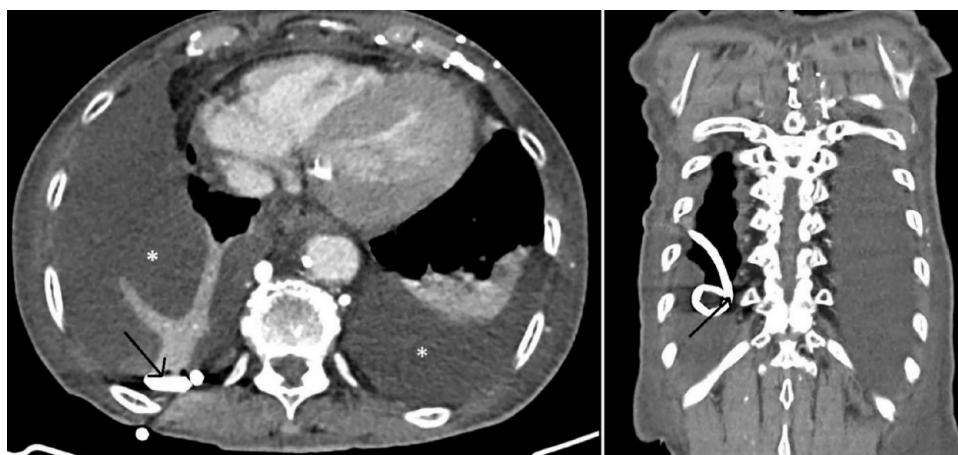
Selected axial (left) and coronal (right) cuts of contrast enhanced chest CT scan done for the patient demonstrating bilateral pleural effusions (asterisks) and the tip of a right sided PleurX tube (arrow).
